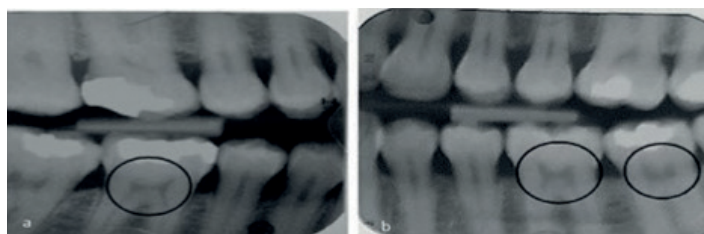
a) X-ray (vitamin D deficiency), (b) X-ray (normal vitamin D level)⁽⁸⁷⁾
